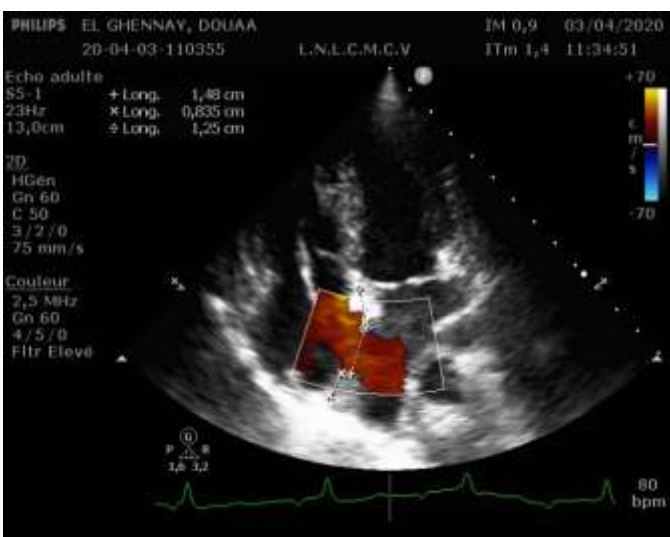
View of the pacemaker probe and the left shunt right in apical with color doppler
